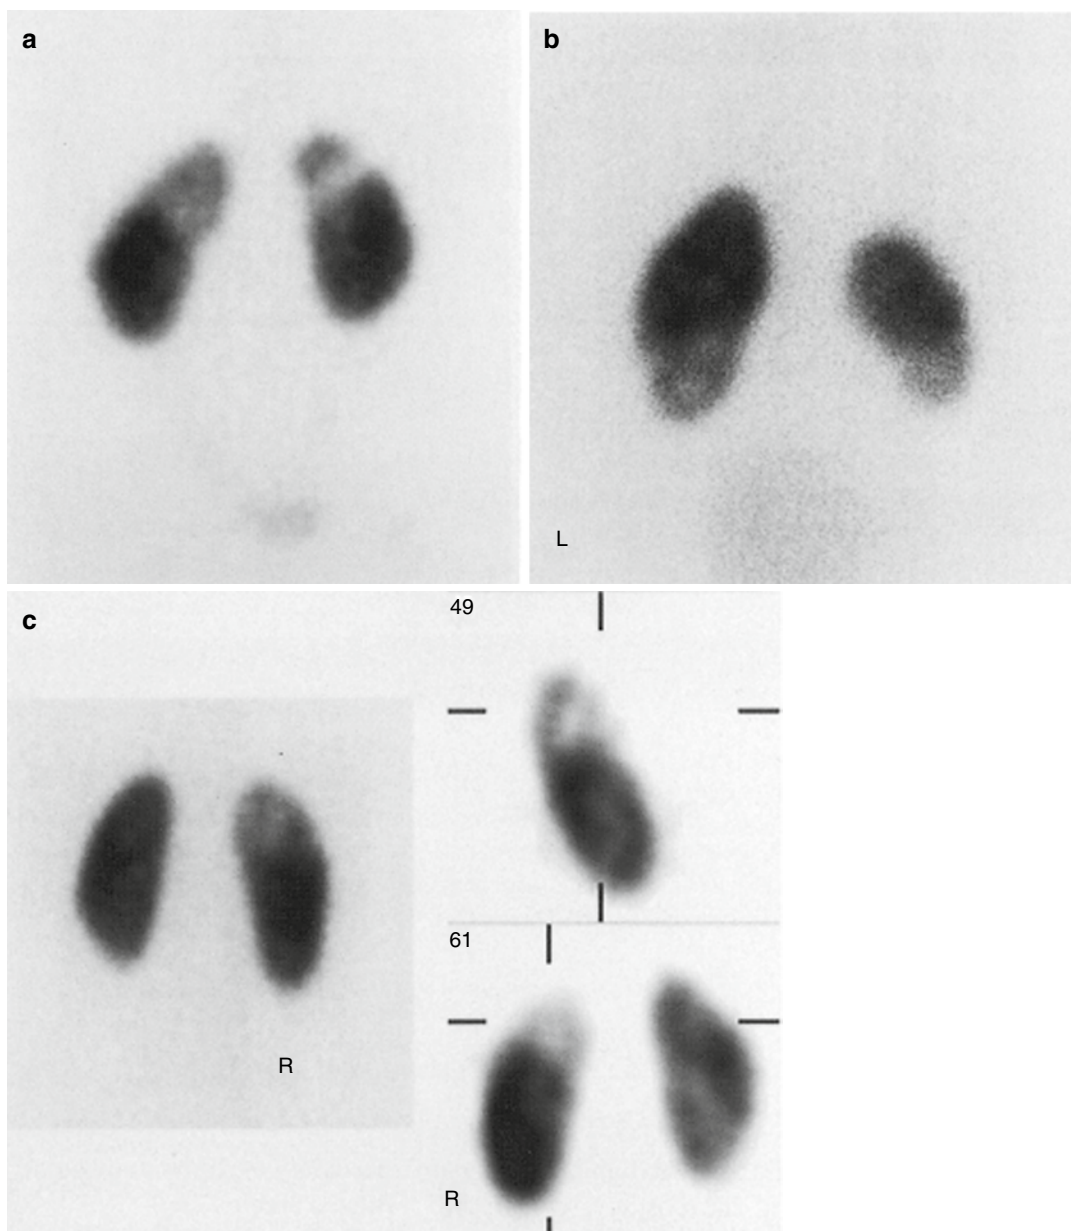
Renal duplication. Three examples of ^{99m}Tc -DMSA scintigraphy in kidneys with duplication. (a) Bilateral duplication with relatively poor function in both upper moieties. (b) Bilateral duplication with less function in the smaller right kidney and in both lower moieties.
